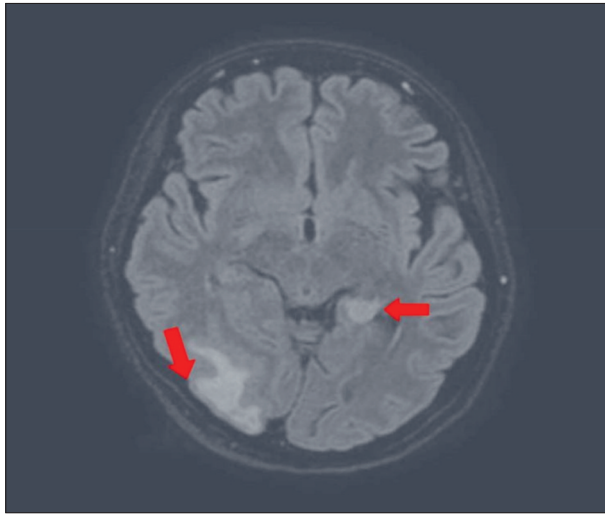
Increased signal intensity in right occipital and bilateral medial temporal lobes on flair sequence MRI
